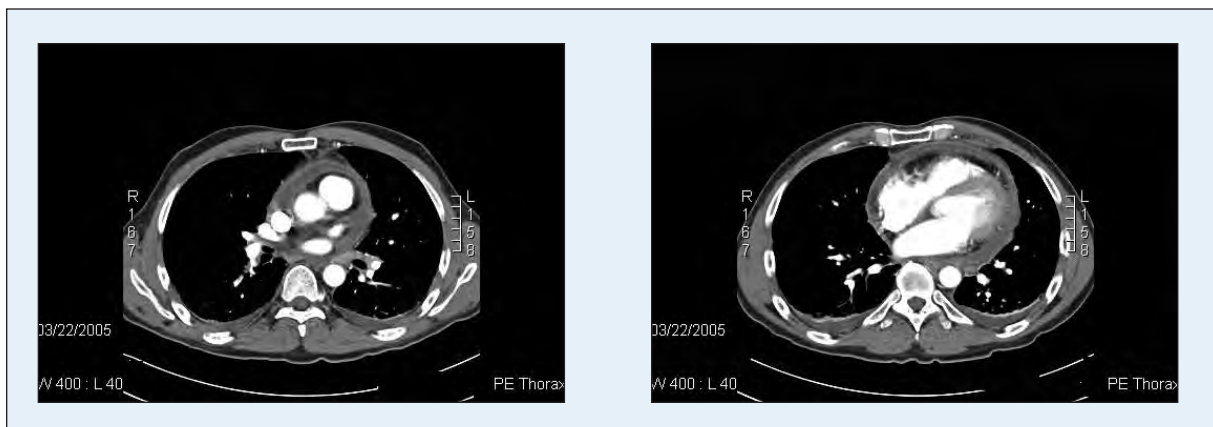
Chest CT Scan before and after treatment.
